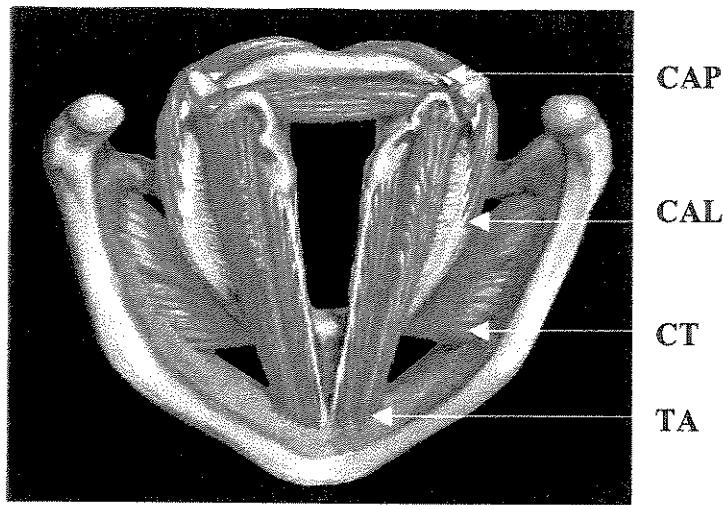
Anatomia da Laringe (músculos intrínsecos): vista superior. CAP – *cricoaritenoideus posterioris*; CAL – *cricoaritenoideus lateralis*; CT – *cricotireoideus*; TA – *tireoaritenoideus*; (Modificado de Netter, 1986).
